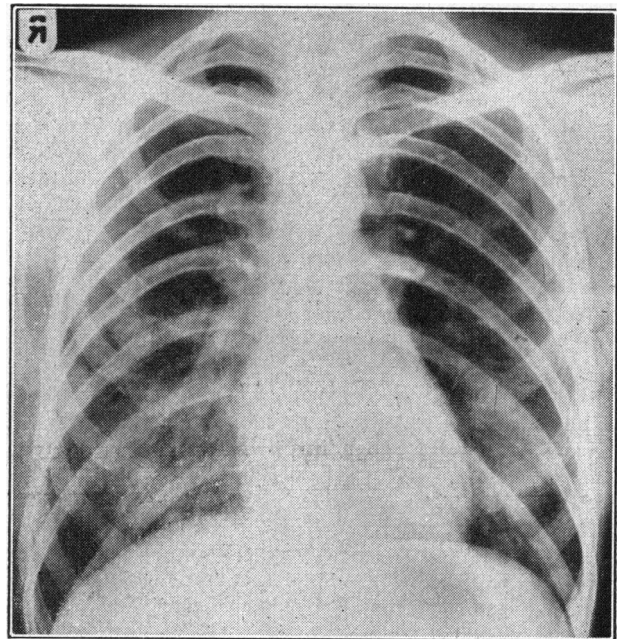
Chest x-ray film after three weeks' treatment.
